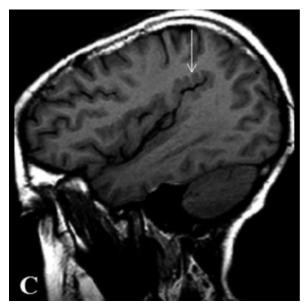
10-year-old girl with Klippel Trenaunay Syndrome. (C) Sagittal T1 weighted MRI of the brain shows the undulated borders of the perisylvian cortex posteriorly representative of polymicrogyria (arrow).
